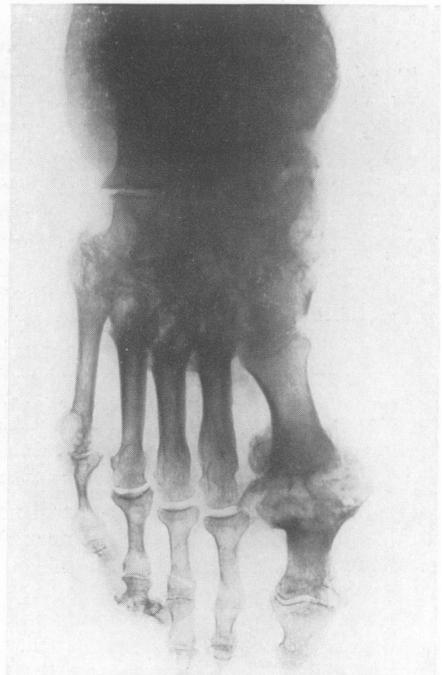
Clinical photographs and radiographs of a patient suffering from a gross form of chronic gout.
